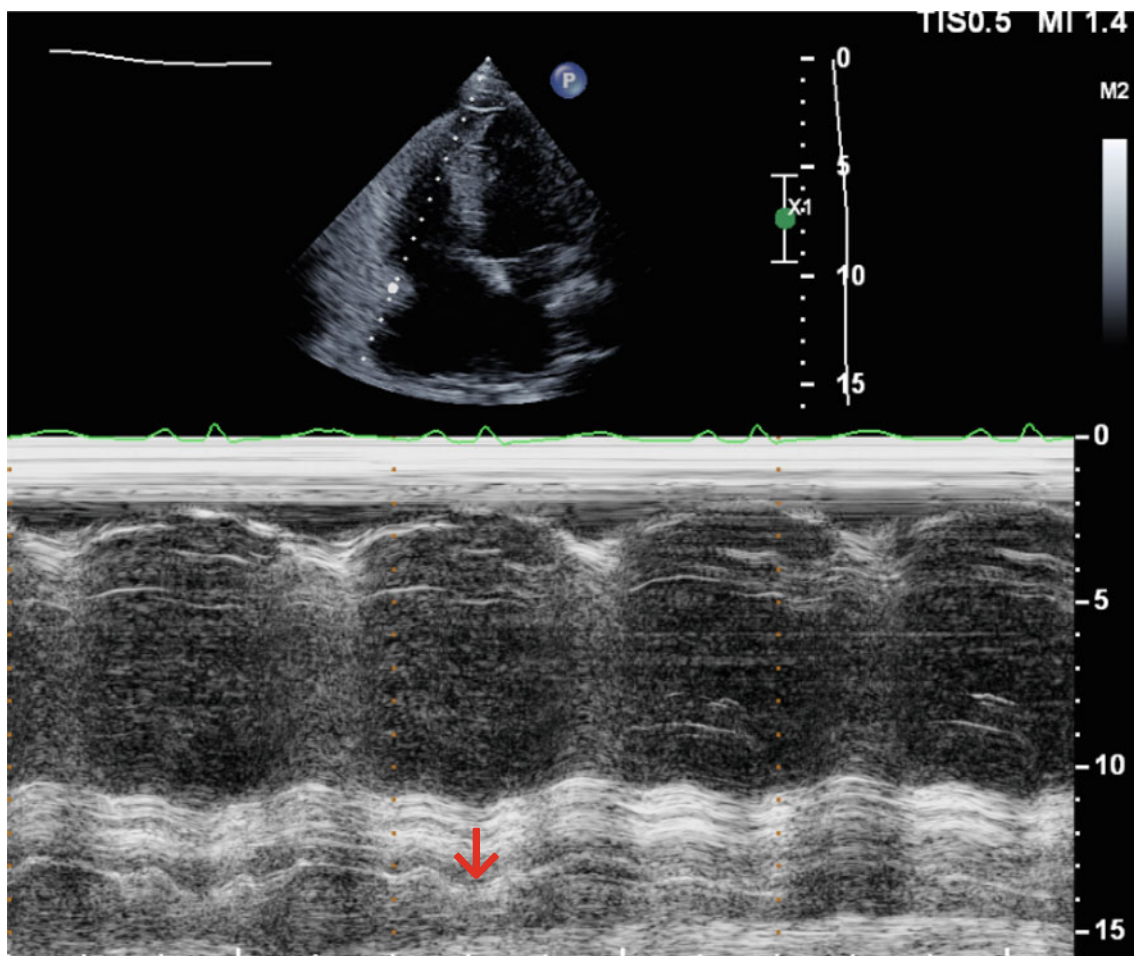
Transthoracic echocardiogram: reduced RV function by tricuspid annular plane systolic excursion (TAPSE) red arrow
